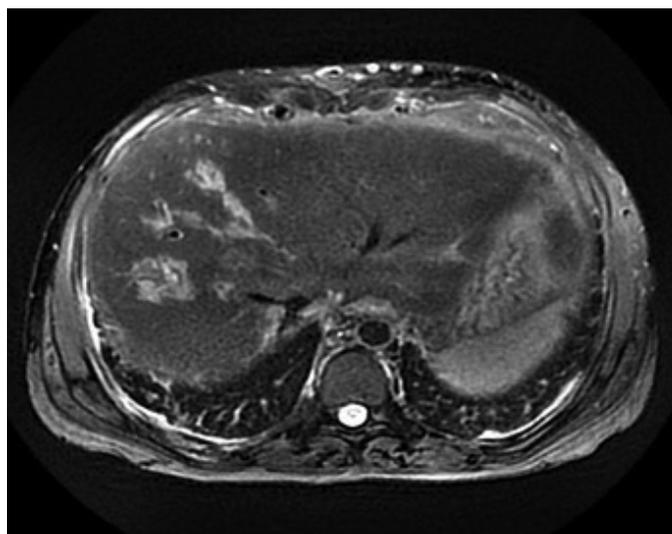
Lesions with T1W hypointense with peripheral enhancement and diffusion restriction observed along the right-middle hepatic vein traces on dynamic MR imaging of abdomen
